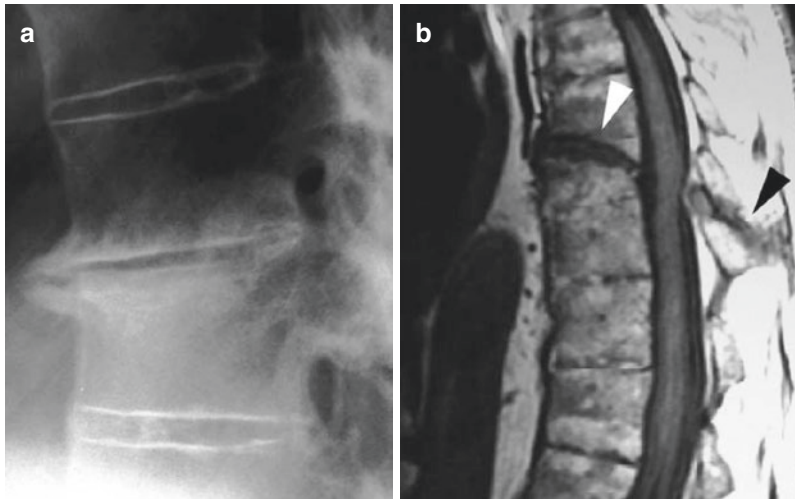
Vertebral fracture. Lateral radiograph (a) demonstrates new bone formation indicative of abnormal motion between two ankylosed spinal segments. Six months earlier, a previous radiograph (not shown) showed a transdiscal fracture that had not been diagnosed. Sagittal
